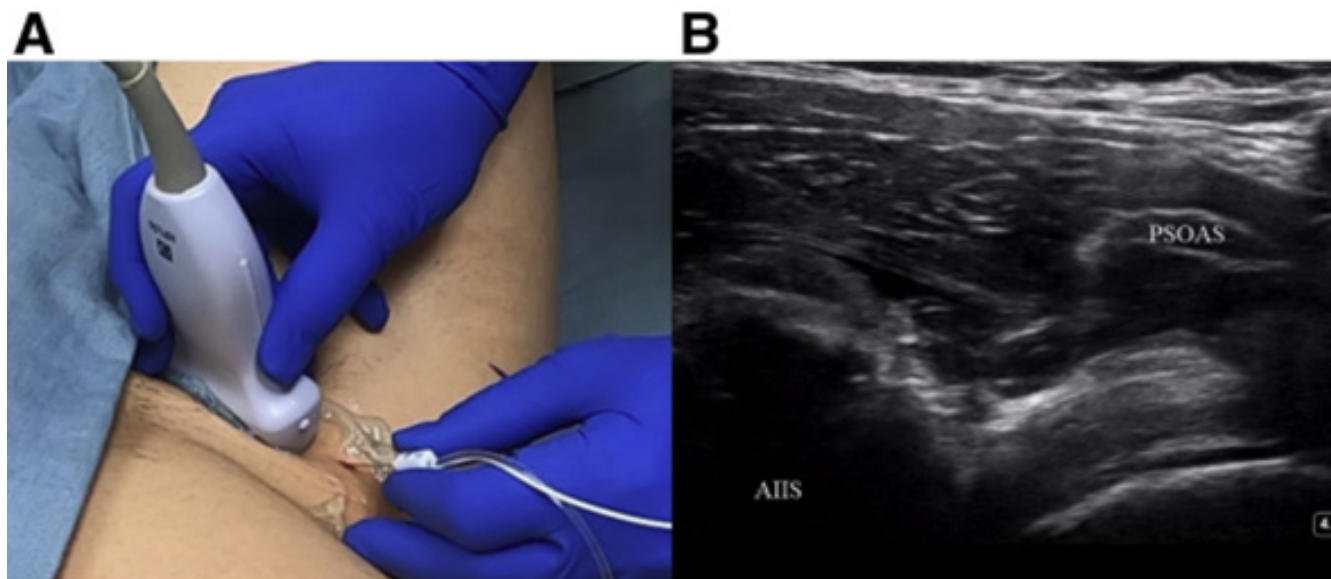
Position of the needle for the PENG block. A. With the probe aligned, the needle is inserted at a 50 ° angle from lateral to medial. B. View of the ultrasound after the injection of the anesthetic, demonstrating the increase in fluid under the psoas tendon.
